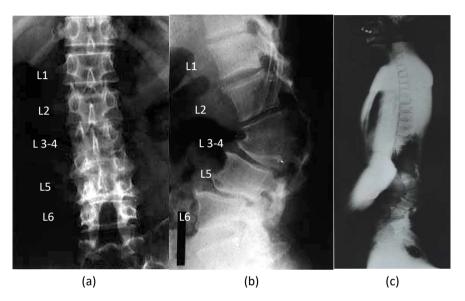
Plain X-ray radiographs before surgery. (a) Anteroposterior view of six lumbar vertebrae, with L6 laminectomised. (b) Lateral view of a L3-4 unsegmented bar with 54° kyphosis and retrospondylolisthesis of L5. (c) Full-length lateral standing view showing lumbar lordosis of 5°.
